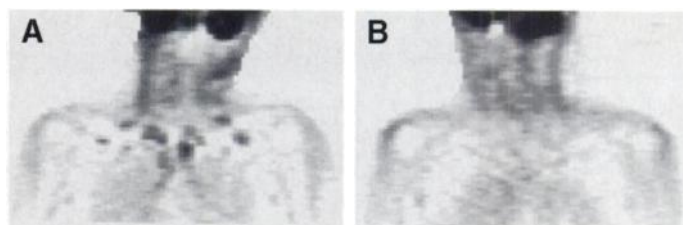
(A) Foci of increased uptake of FDG in the region of the neck and mediastinum, reported as representing malignancy. (B) Repeat scan 13 days later shows complete resolution of supposed “malignant” uptake.
